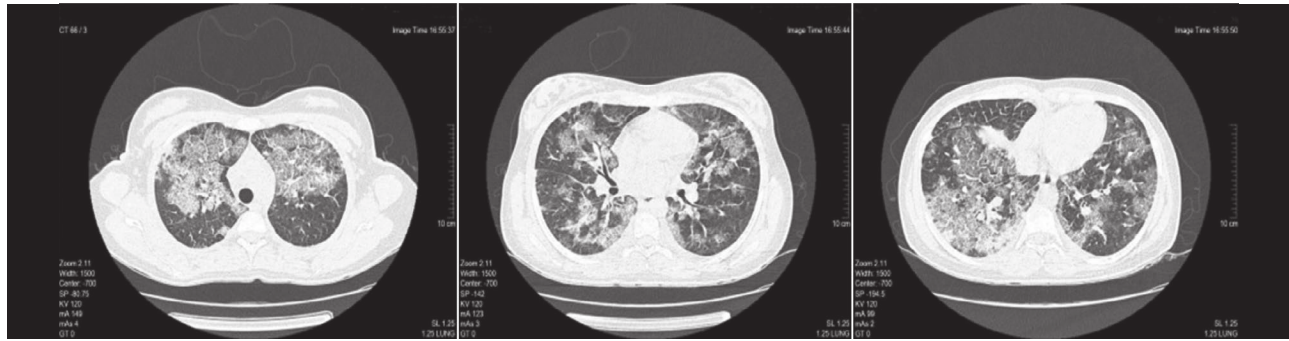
Patient's computed tomography (CT) of chest sections showing a "crazy paving" pattern.
